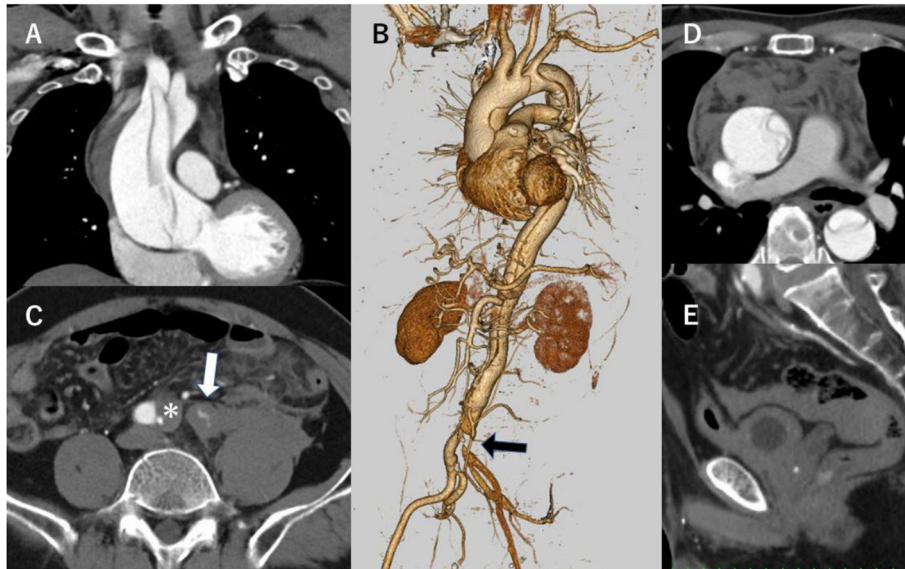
Preoperative computed tomography. (A) Acute type A aortic dissection with entry into the ascending aorta. (B) The left common iliac artery's malperfusion. (C) Expanded false lumen of the left common iliac artery (*) and retroperitoneal extravasation (↓). (D) Massive hemorrhage in the anterior mediastinum. (E) Ascites in the rectovesical pouch.
